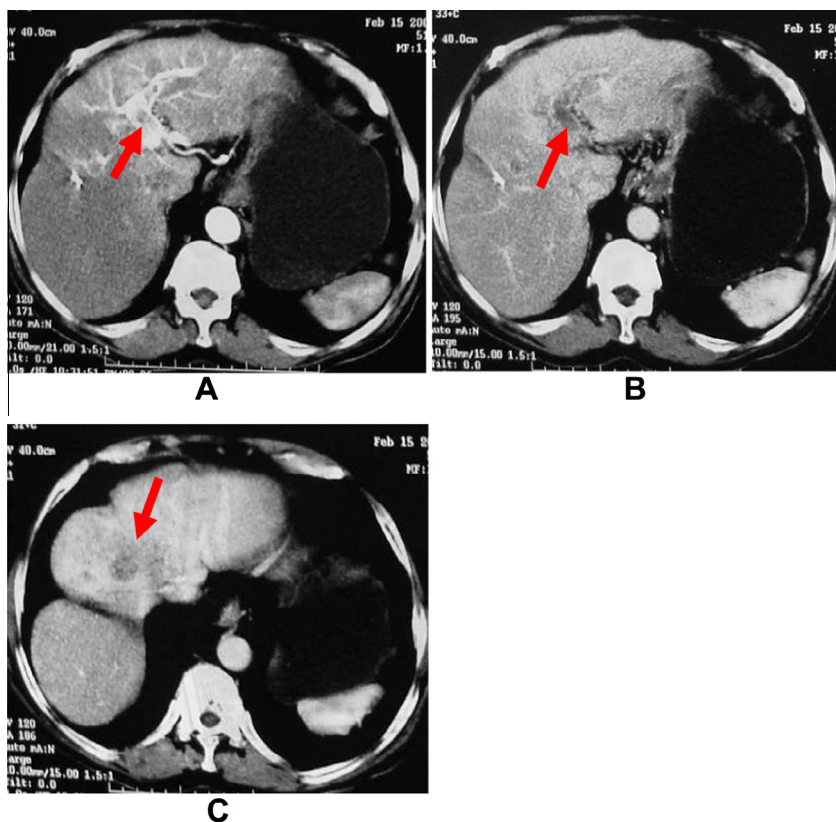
Mixed severe APS: 75 year old male patient with liver cirrhosis and nodular HCC at segment IV of the relatively hypertrophied left lobe. (A) Axial CT cut at the arterial phase shows enhancement of the left portal veins as far as the 2nd order branches, with ill defined intra-luminal filling defect at the left main portal vein (red arrow). (B) Partial thrombosis of the left portal vein is confirmed at the portal venous phase (arrow head). (C) The HCC is better seen at the venous phase due to wash out of the contrast (arrow).
